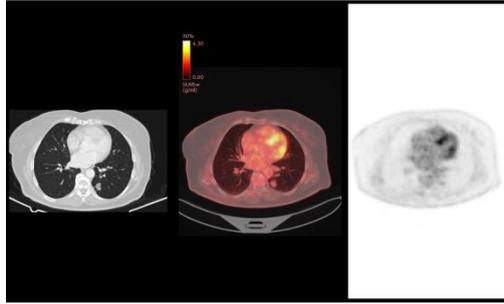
62 years old patient treated of left colon cancer, stage I. 2cm lung nodule is spotted on the first follow up CT. PET/CT showed low avid lung nodule, most likely benign. Follow up CT exams showed no signs of progression nor other malignant lesions were detected.
